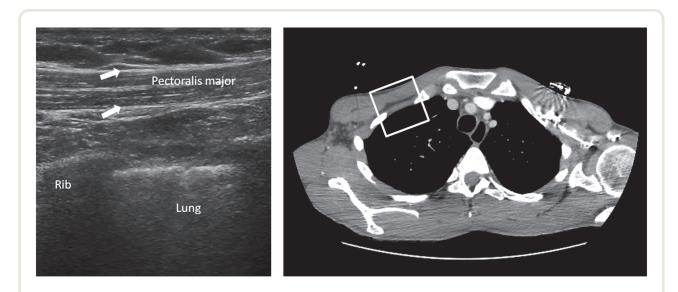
Ultrasound image of the pectoral muscle under the clavicle (left panel), and comparative computed tomography scan (right panel). The pectoralis major is outlined by its two fasciae (*arrows*) and stands out in front of the pectoralis minor (visible on the left).
